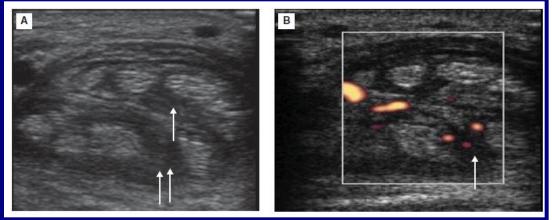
A Transverse image at carpal tunnel showing hypoechoic synovial hypertrophy (white arrows) surrounding the flexor digitorum superficialis (single arrow) and flexor digitorum profundus tendons (double arrow) consistent with tenosynovitis. B Transverse scan showing increased vascularity on power Doppler. (6)
